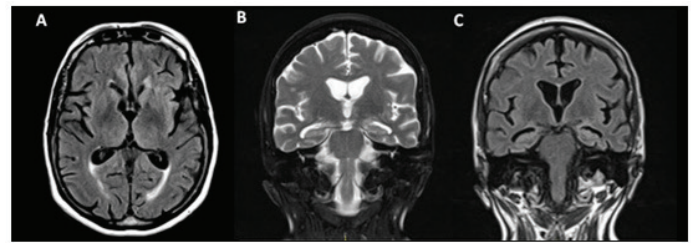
FLAIR axial brain MRI (A), T2-weighted (B) and FLAIR (C) coronal brain MRI, showing global brain atrophy, more evident in posterior temporal lobes and left insula and hippocampus. A 68-year-old woman, presenting language difficulties in the last two years. She started with slow and paused speeches, but comprehensible. These characteristics gradually evolved towards an unintelligible talk, ungrammatical utterance and phonological paraphasias. On neurological examination, it was found anomia and a non-fluent speech, even with efforts, however word and objects recognition were preserved. Based on these clinical features, the diagnosis of nfvPPA was made and the multidisciplinary treatment with speech therapy and music therapy was performed.
